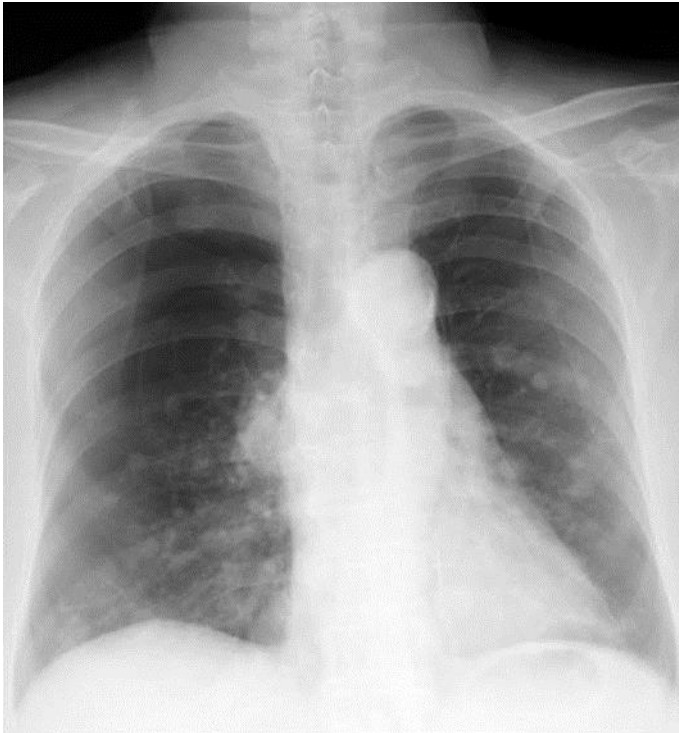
Chest X-ray demonstrating multiple lung metastases of sarcoma and bilateral pneumothorax.
